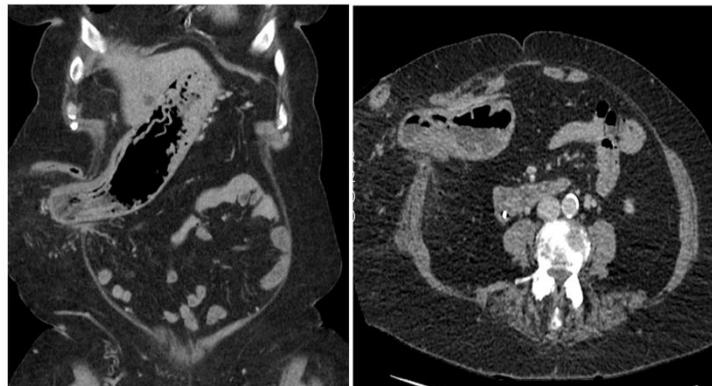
CT abdomen and pelvis showing stomach in the parastomal hernia
